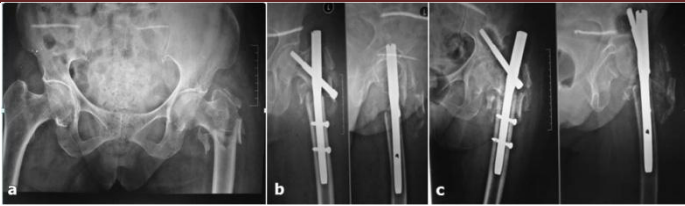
Radiograph of pelvis anteroposterior view (a) showing comminuted intertrochanteric fracture left femur, immediate postoperative radiograph (b) and follow up radiograph anteroposterior, lateral view (4c) showing screw cut out and non union.
